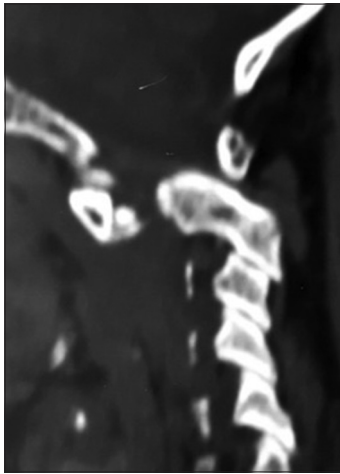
Computed tomography – Sagittal view showing complete displacement of C1-C2 segment
